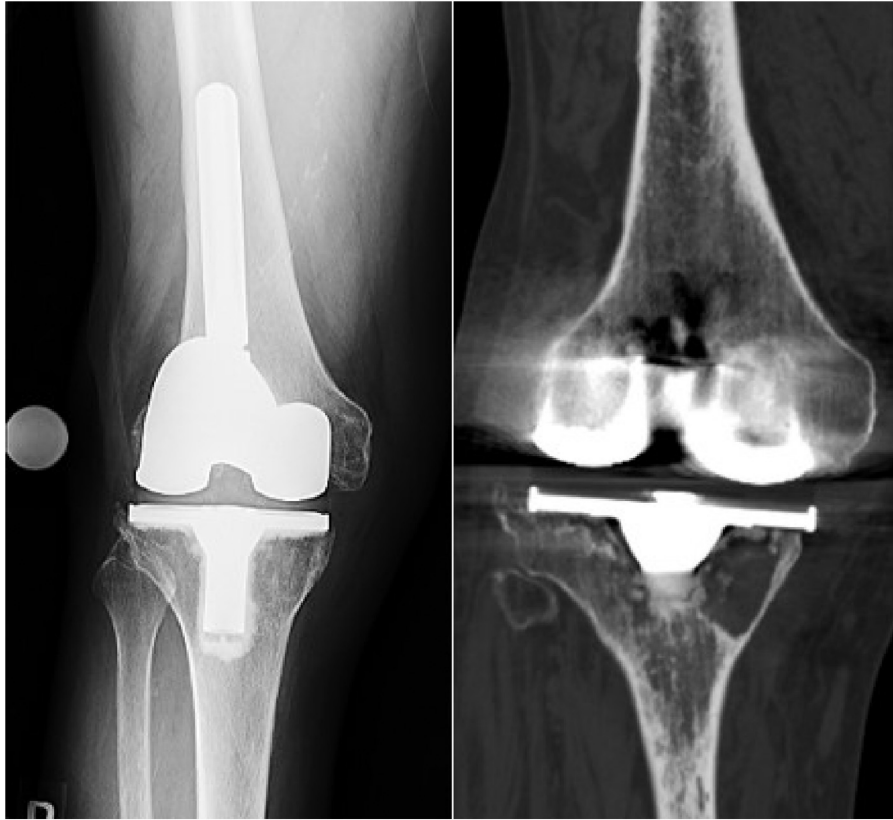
Case 2: Preoperative anteroposterior radiographs and coronal computed tomography images showing a defect in the proximal tibia and loosening of the tibial component.
